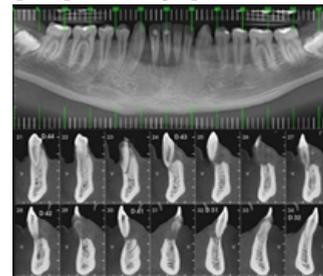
Cone beam computed tomography. Panoramic reconstruction and cross sections.
